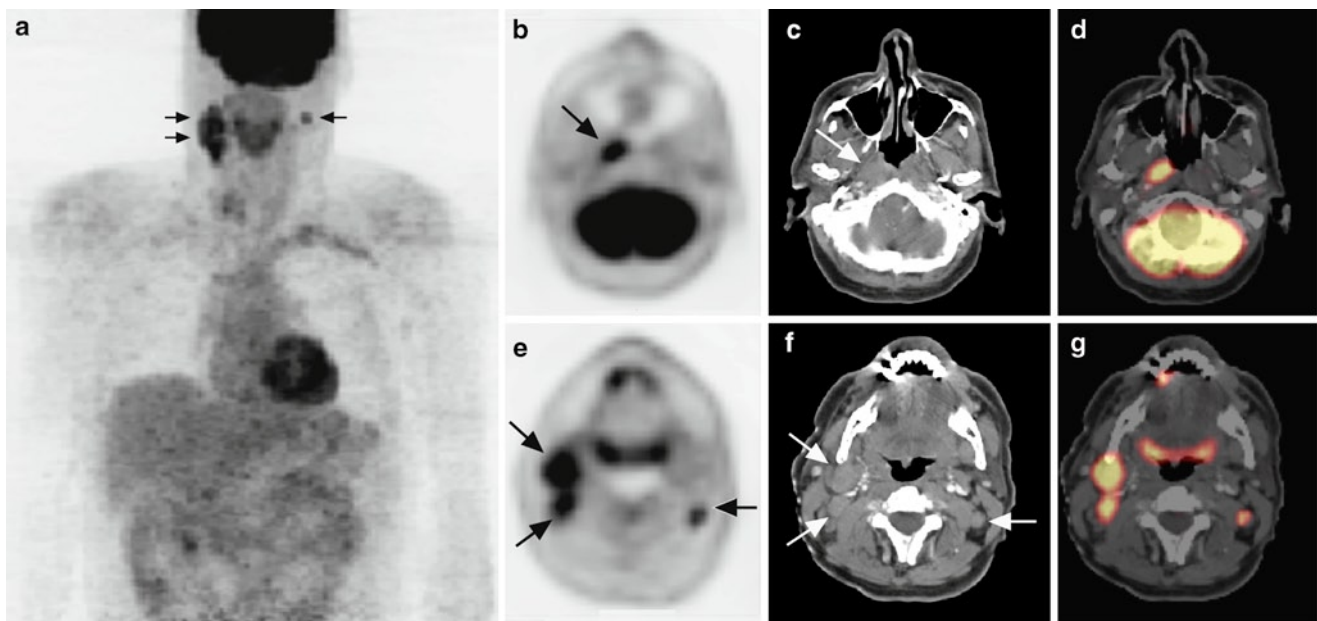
Patient presented with bilateral lymph nodal neck masses. PET/CT reveals unknown primary neoplasm of nasopharyngeal squamous cell carcinoma. (a) MIP PET image demonstrates bilateral increased abnormal FDG uptake in the neck (*black arrows*). (b) Axial PET in the region of nasopharynx shows focal abnormal FDG uptake in the region of the right torus tubarius (*black arrow*). (c) Axial CT of nasopharynx shows mild soft tissue fullness in the same region (*white arrow*). (d) Axial PET/CT demonstrates increased abnormal FDG uptake in the region of mild soft tissue fullness representing primary
